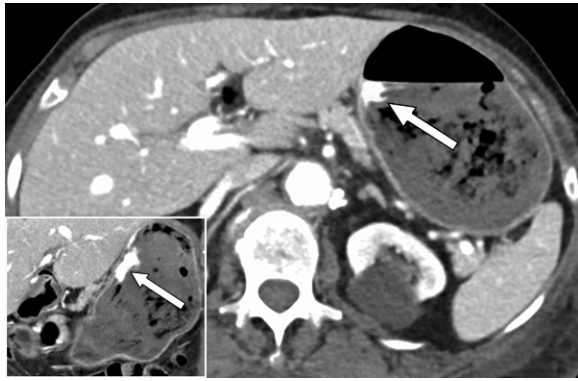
Gastric ulcer causing active bleeding in an 80-year-old woman receiving enoxaparin and warfarin for chronic atrial fibrillation and aortic valve replacement who underwent recent spinal fusion surgery. Axial (main image) and coronal (inset) portal venous phase CT images show contrast extravasation along the lesser curvature of the stomach (arrow in both images). Figure E1 is an upper endoscopic image in this patient that shows an actively bleeding ulcer in the lesser curvature of the stomach.
